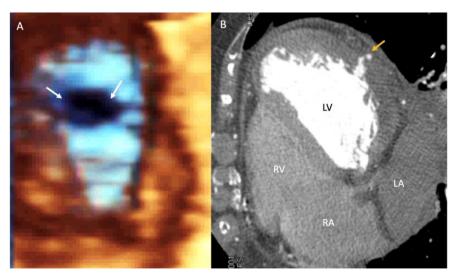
2D and 3D transthoracic echocardiogram. (A) 3D echocardiogram with an internal view of free wall rupture (white arrows); (B) CT 4-chamber view showing free wall rupture with mild pericardial effusion (orange arrow). Abbreviations as before.
